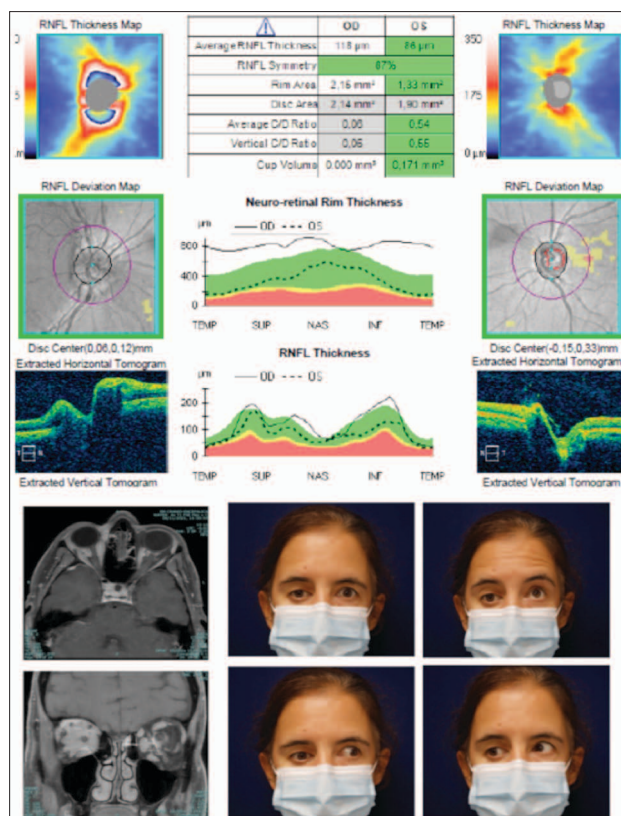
Clinical presentation, OCT and orbital findings before treatment. (A) The OCT reveals a optic disc edema of the right eye. (B) Orbit axial and coronal T1 MRI showing post-gadolinium enhancing lesions (intra and extra-conal), with mass effect and inflammatory changes of orbital fat. (C) Right inferior dystopia with restriction in extraocular elevation and adduction of the right eye.
